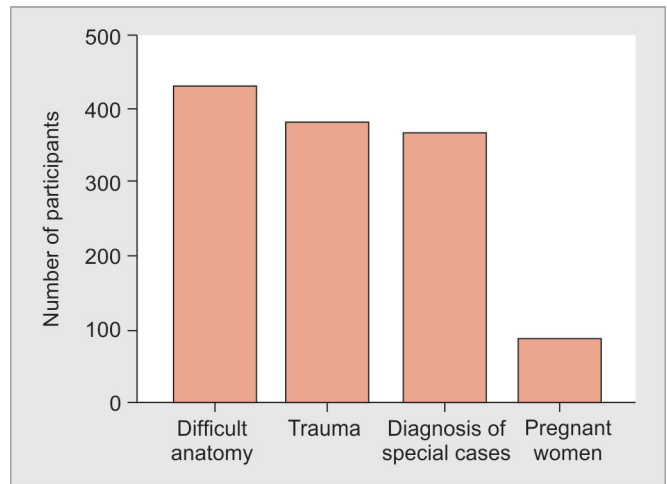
Specific application of CBCT
